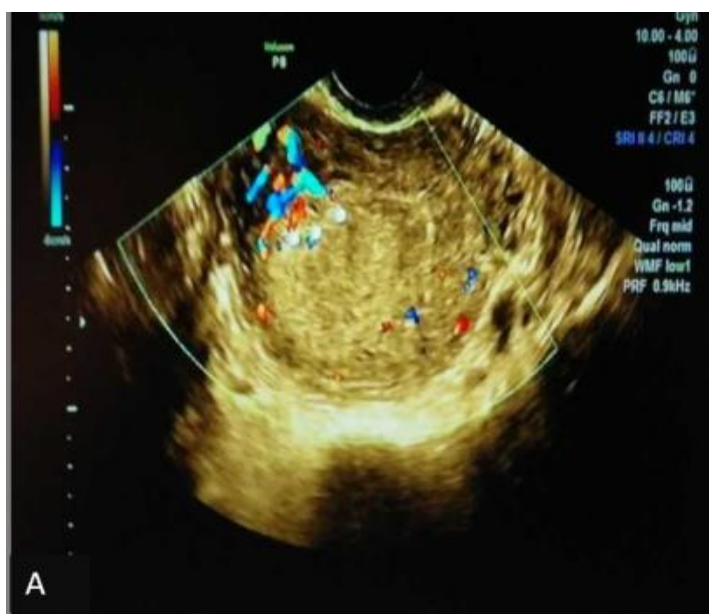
A: Pelvic B-ultrasound (preoperative)
